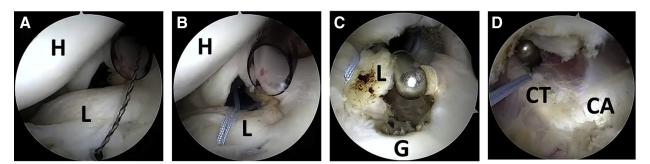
Traction suture placement and capsular transection in left shoulder in lateral decubitus position viewed from the posterior portal. (A) The suture passer is placed in the anterosuperior labrum for passage of the traction suture. (B) A racking hitch knot is used to secure the traction suture to the anterosuperior labrum. (C) Transection of the anterosuperior glenohumeral capsule superior to the traction suture. (D) Transection is continued until the conjoint tendon and coracoacromial ligament are visualized. (CL, coracoacromial ligament; CT, conjoint tendon; G, glenoid; H, humerus; L, labrum.)
